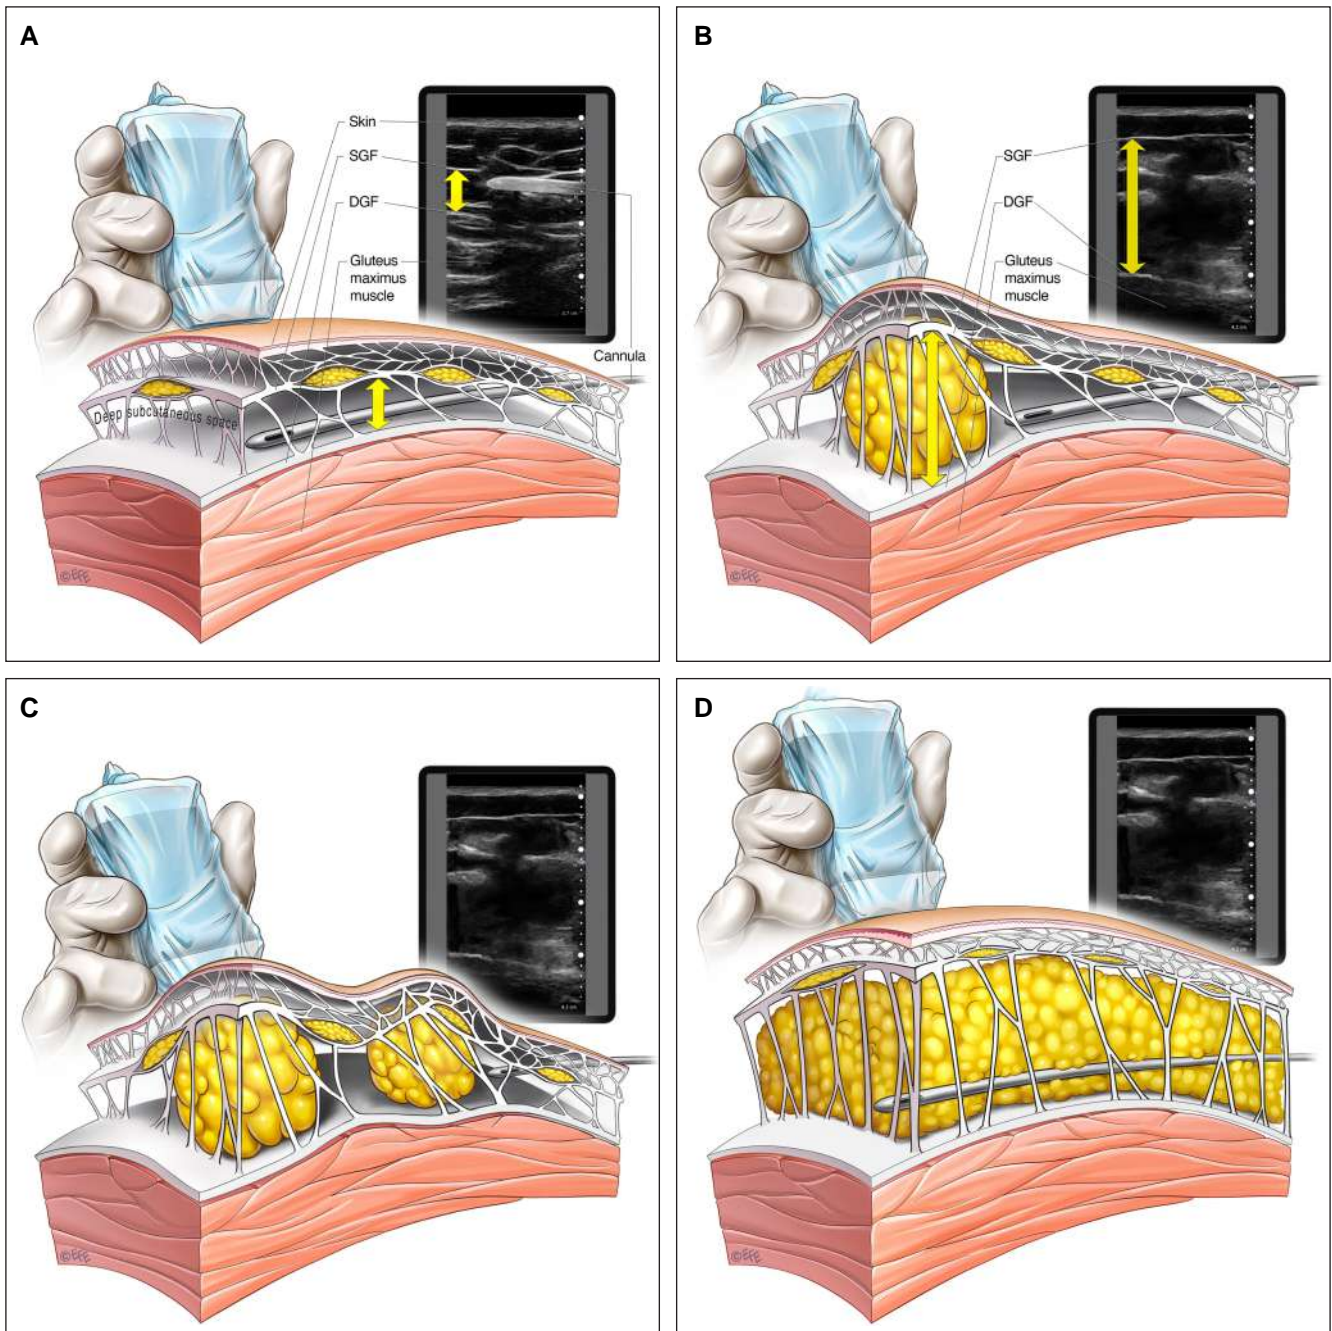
SIME technique: ultrasound probe and cannula position. (A) The ultrasound probe is placed on the skin over the first site of fat graft injection, typically at the center of the gluteal dome (Figure 5A). The injection cannula is inserted through the skin and advanced towards the ultrasound probe. The surgeon uses the ultrasound to visualize all subcutaneous structures and confirm the position of the cannula in the deep subcutaneous space, below the SGF and above the DGF. The height of the unexpanded deep subcutaneous space is noted (small yellow double-headed arrow). (B) Once the cannula position has been confirmed to be above the DGF, the cannula remains stationary and fat graft is injected (static injection). Fat graft migrates easily through the deep subcutaneous space (migration). During the injection, the surgeon assesses the external gluteal contour and stops the static injection when sufficient gluteal projection has been achieved. The ultrasound will confirm a doubling or tripling of the height of the deep subcutaneous space (large yellow double-headed arrow). (C) Once the desired projection and aesthetic endpoint of the first site has been achieved, the ultrasound probe is moved to the next injection site. The cannula is again advanced to the probe. Once the position of the cannula has been confirmed to be above the DGF, the cannula remains stationary and fat graft is injected at the second site (Figure 5B). (D) After all sites have been injected, the surgeon can use the cannula in a dynamic fashion to equalize the fat graft between the areas of injected fat to correct irregularities (equalization). Fat graft is only injected under ultrasound visualization and never when the cannula is in motion. DGF, deep gluteal fascia; SGF, superficial gluteal fascia; SIME, static injection, migration, and equalization.
